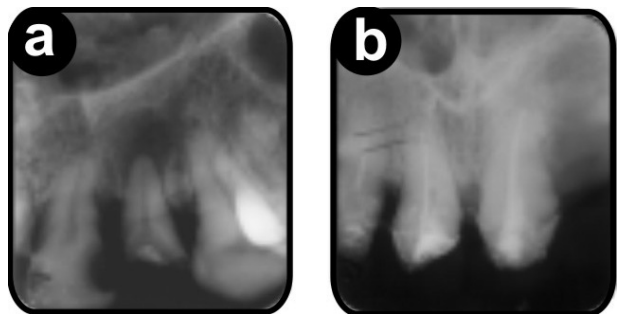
X-ray findings in Case 3. a: The pretreatment X-ray image shows a maxillary cystic granuloma complicated with sinusitis of endodontical origin. b: X-ray image showing the infected area after the extraction of the granulomatous tooth.
